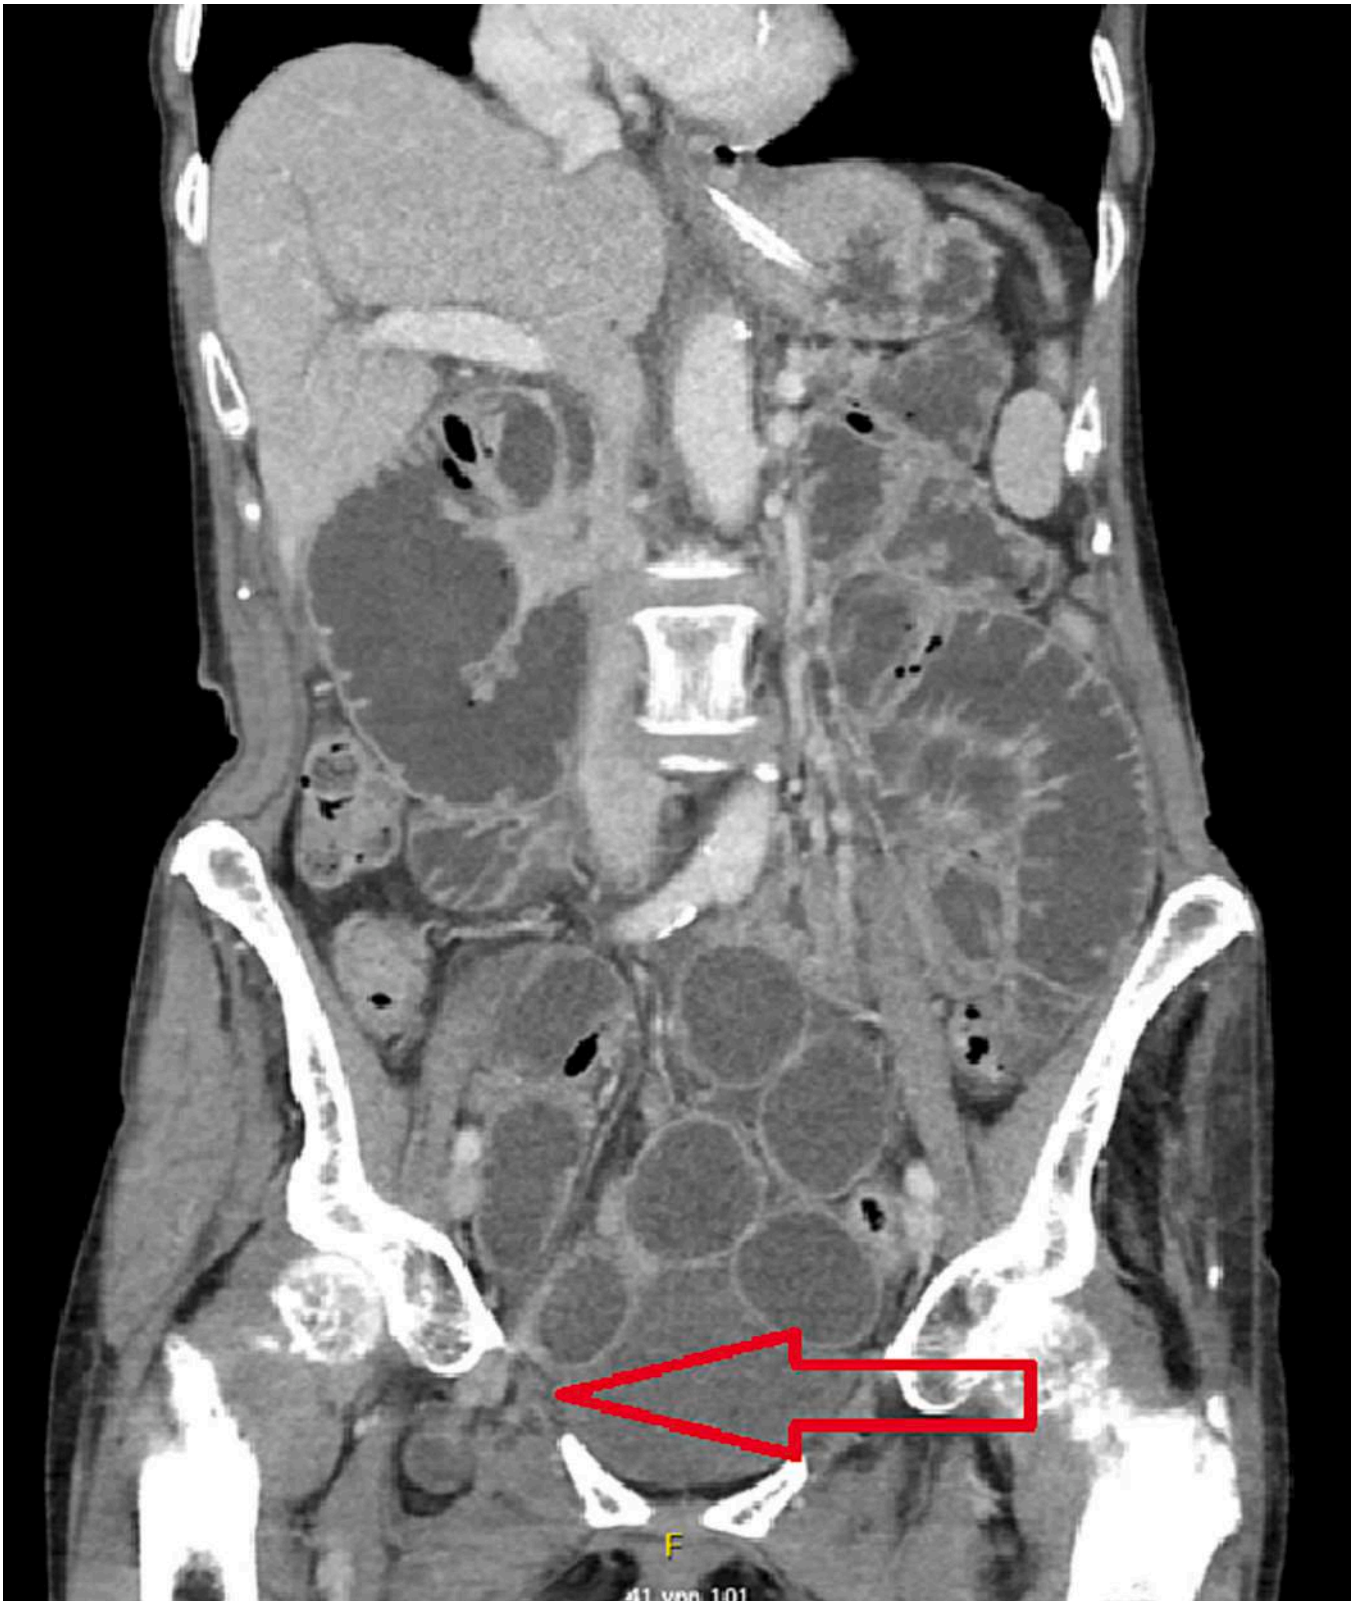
Coronal overview of the abdominal CT-scan with contrast. A distended bowel is diagnosed and a clearly Obturator hernia is visible with its incarcerated bowel content (arrow).
